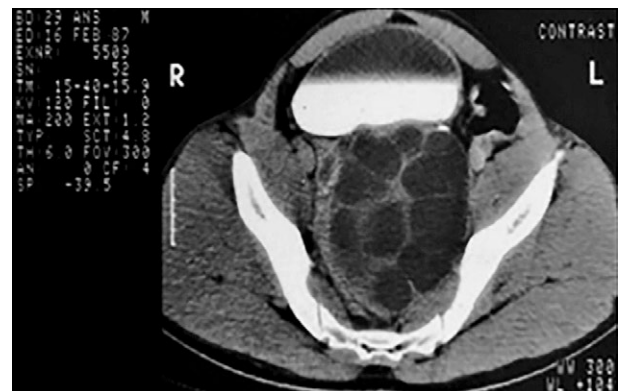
Pelvic hydatid cysts. Gharbi's classification type III. A 29-year-old woman presents with hypogastric pain and frequency of micturition. Axial contrast enhanced CT (CE-CT) demonstrates a large multi-loculated cystic lesion in the retrovesical region of the pelvis, displacing the bladder anteriorly. No mural nodule, soft tissue component or calcifications were seen within the lesion.
